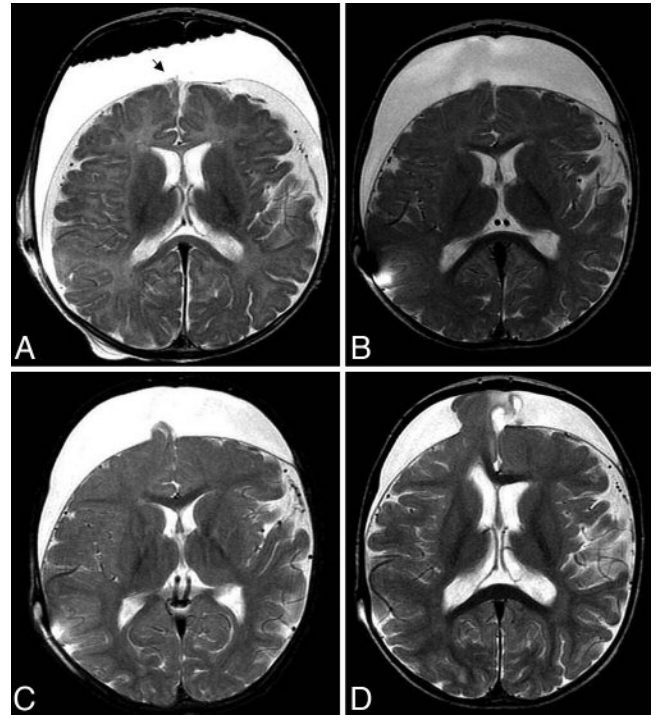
Axial T2-weighted MR images of the brain at relatively similar planes of section performed at 4 months of age immediately following subduroperitoneal shunt insertion (A); 7 months of age (3 months after shunt placement [B]); 10 months of age (6 months after shunt placement [C]); and after presentation with new onset seizures at 12 months of age (8 months after shunt placement [D]). The area of cortical herniation is visible on the initial study (arrow in A) and clearly worsens over time.
